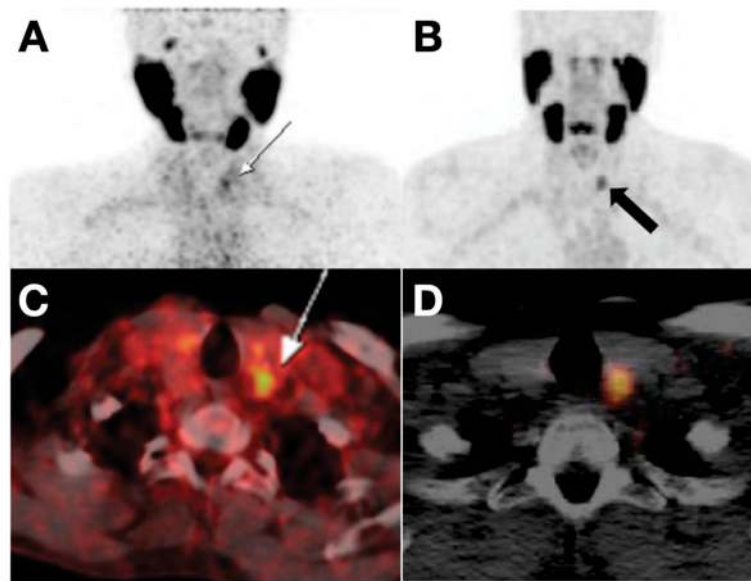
(A,C) PET and PET/CT fusion images showed slight ^{68}Ga Ga-PSMA uptake in the thyroid nodule of a 62-year-old patient with prostate cancer. The thyroid nodule was validated as Hürthle cell angioinvasive FTC by post-thyroidectomy pathology. Reproduced with permission from [88] copyright 2016 Society of Nuclear Medicine and Molecular Imaging. (B,D) PET and PET/CT fusion image marked ^{68}Ga -PSMA uptake in the thyroid nodule of a 65-year-old man with metastatic prostate cancer. The thyroid nodule was regarded as TC proved by post-thyroidectomy pathology. Reproduced with permission from [91], copyright 2017 Wolters Kluwer Health Inc.
